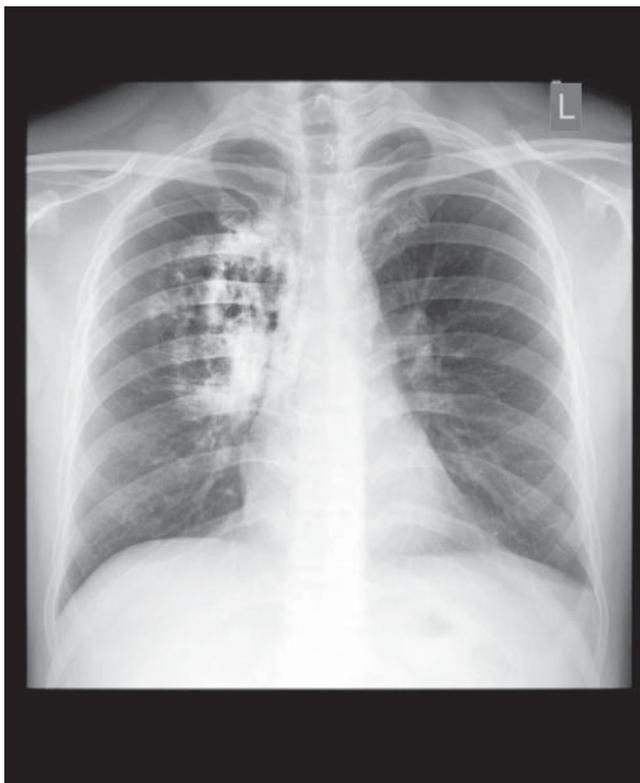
Lung cancer X-ray image.
